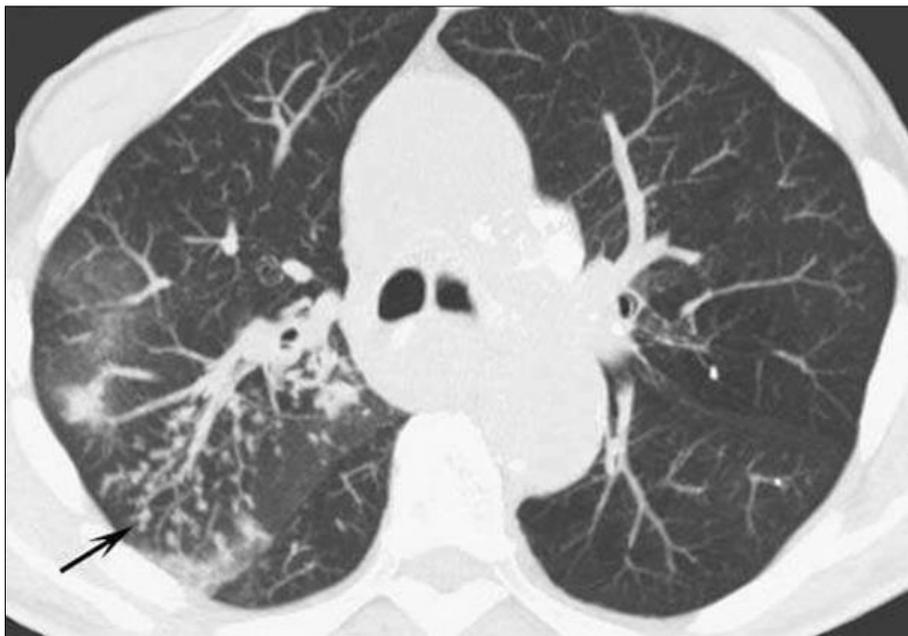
Centrilobular nodules with tree-in-bud pattern on HRCT imaging.
